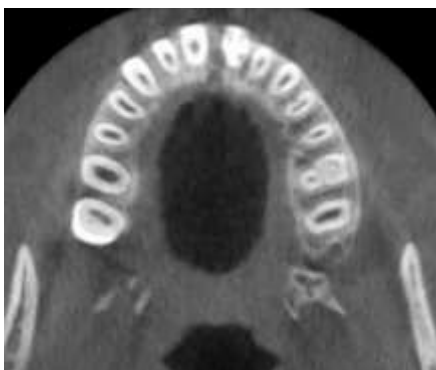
Axial view of the CBCT showing bone resorption adjacent to the tooth #9.
